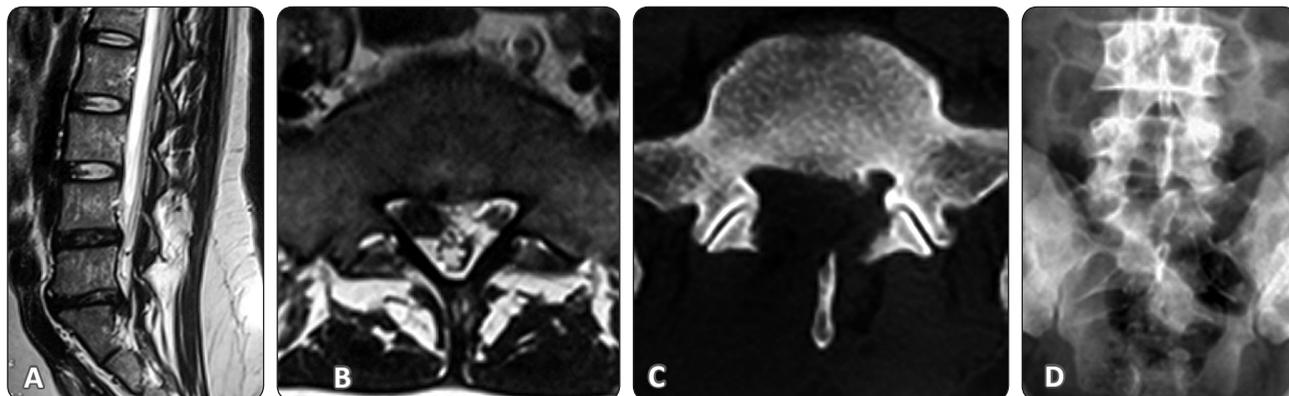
Images of female patient 29 years old complaining of low back pain and right sciatica along right S1 distribution. (A,B) MRI lumbosacral spine T2W image sagittal and axial views showing right L5-S1 lumbar disc prolapse. (C) CT scan bone window, axial view, showing the extent of the fenestration. (D) Plain x-ray AP view, immediately postoperative showing evidence of right L5-S1 fenestration.
